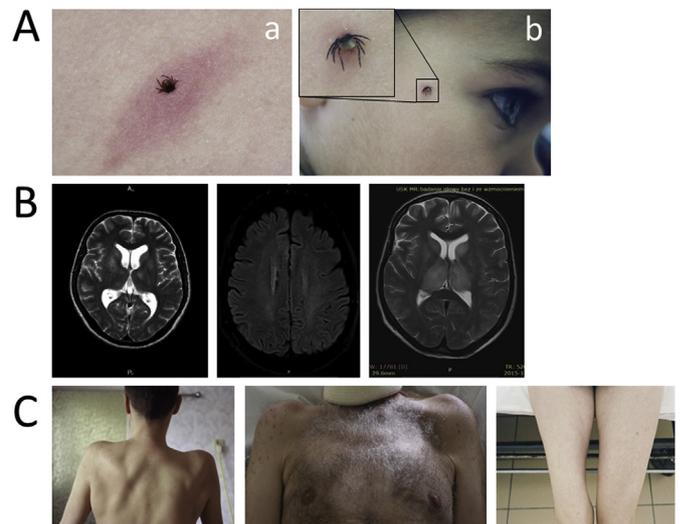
TBE in humans. (A) Tick attachment. In most cases, TBEV is transmitted to humans via the bite of a TBEV-infected tick, mainly *Ixodes ricinus* in Europe and *Ixodes persulcatus* in Russia. (a) Tick bite with nonspecific skin reaction. Nonspecific reactions around the site of tick bite are common and usually disappear quickly, without any clinical significance. (b) Tick bite without any skin reaction. (B) The brain is the main target for TBEV in humans. MRI findings are usually normal in TBE patients, but MRI signal abnormalities can be seen in severe TBE cases. Examples of MRI lesions are shown. (C) Inflammation can affect the spinal cord and nerve roots. Examples of muscle atrophy as sequelae of radiculomyelitis are shown. All photographs belong to the authors.
